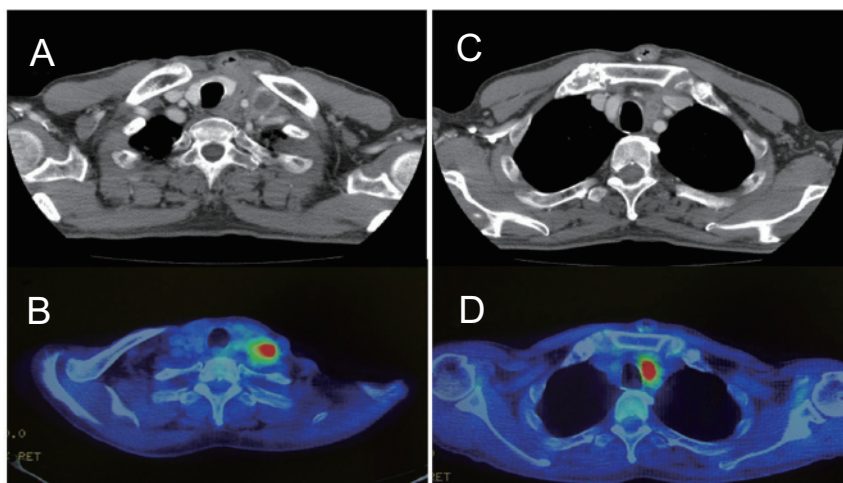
CT and FDG-PET/CT images before chemoradiation with hyperthermia. A, left subclavian mass with central necrosis; B, high FDG uptake in left subclavian mass; C, upper mediastinal mass; D, high FDG uptake in upper mediastinal mass.
